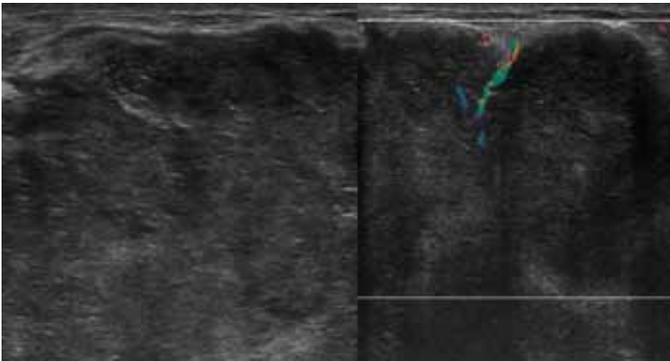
Selected ultrasound images of the left breast mass.
